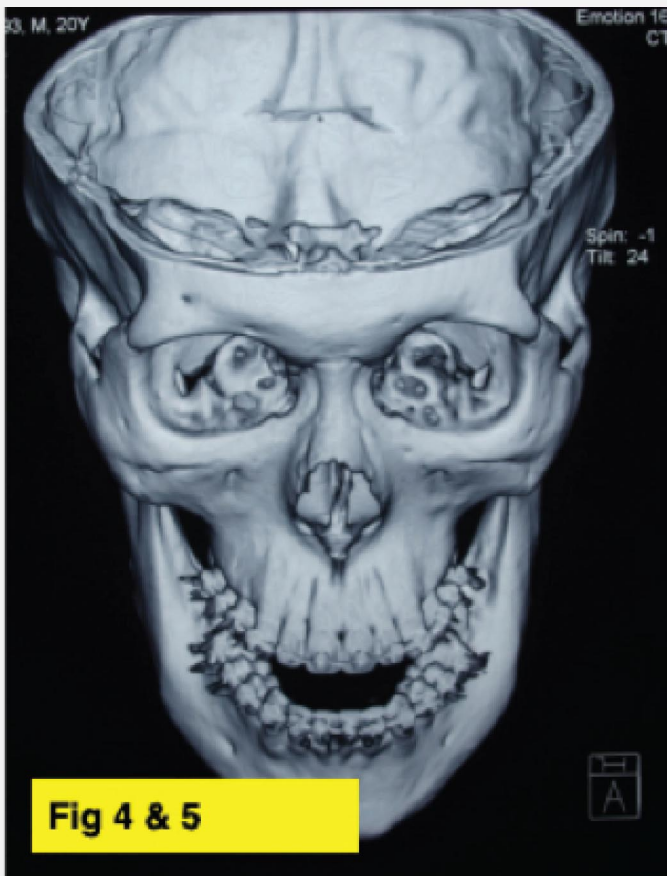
A three dimensional CT Scan shows the mandibular discrepancies.
